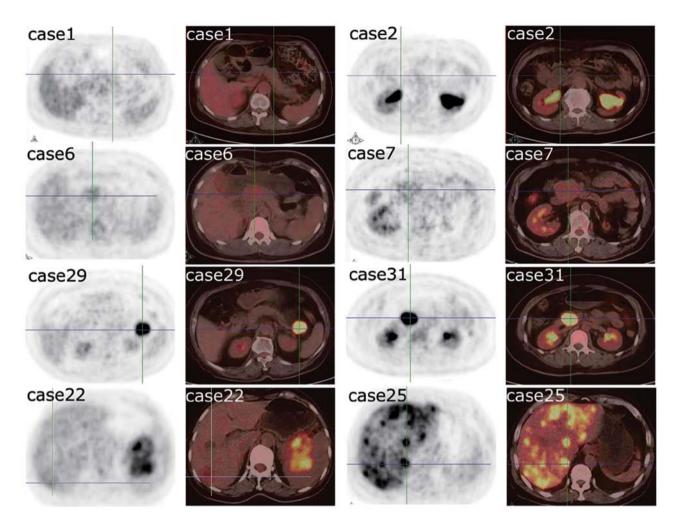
Representative ¹⁸F-FDG uptake and PET/CT scan images in patients with non-functioning PNETs. Primary non-functioning PNETs showed no (cases 1 and 2), mild (cases 6 and 7), and intense (cases 29 and 31) ¹⁸F-FDG accumulation. ¹⁸F-FDG uptake was observed in liver metastatic lesions of 2 patients with non-functioning PNETs (cases 22 and 25).
